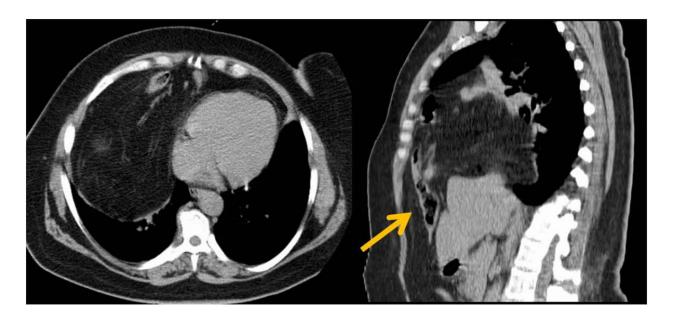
Morgagni hernia. CT scan shows a retrosternal hernia that includes the omentum and colon (arrow).
